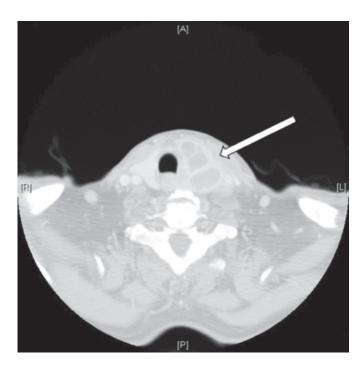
Computed tomography scan of the neck showing a large multiloculated mass of the left lobe and isthmus of the thyroid (40x47x48 mm). The mass had a mixed solid-cystic pattern and was responsible for tracheal dislocation (*arrow*).
